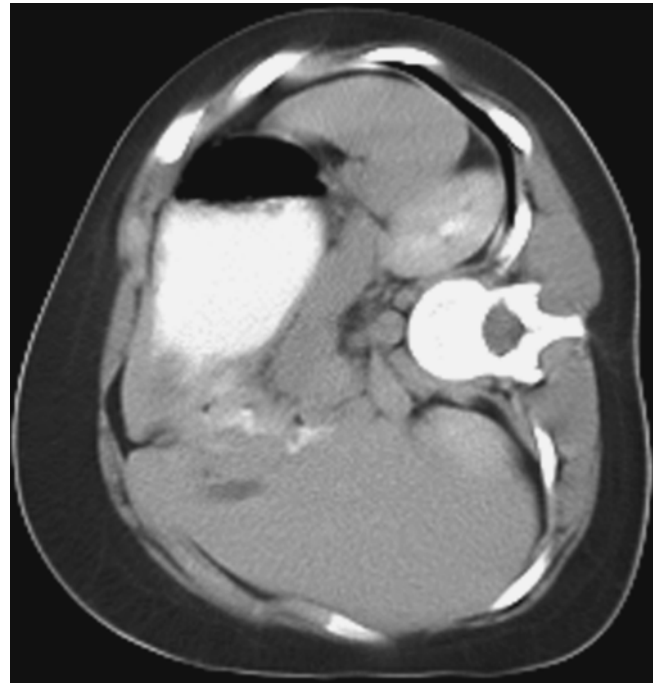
CT scan demonstrating thickened gastric wall due to diffuse infiltration with non-Hodgkin's lymphoma
